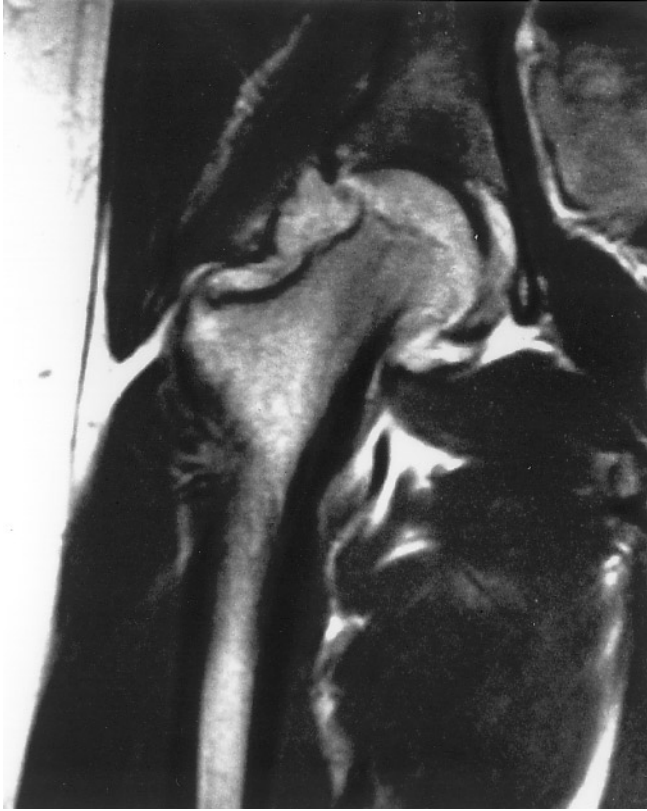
A. Radiograph of the pelvis of a 16-year-old girl shows pressure related erosions of the lateral femoral neck on the right side (arrow) and the beginning of joint space narrowing. She had pain and limited motion for 15 months. B. Coronal T1 weighted Gd enhanced SE MR image shows the synovitic lesion with additional joint effusion and bone erosion. She is free of symptoms 14 months after open synovectomy.
